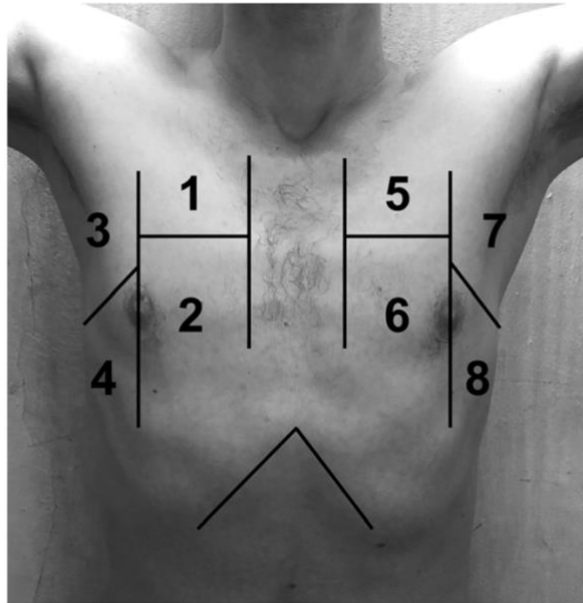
8-zone ultrasound protocol
